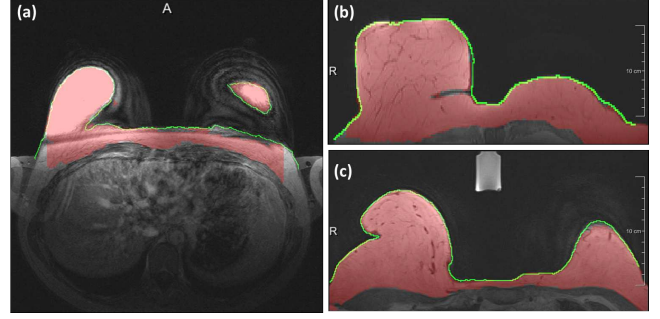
The artifacts and challenges presented in breast MRI, overlaid with the segmented breasts (red masks), and the reference breast-air boundaries annotated by a radiologist (green contours): (a) Presence of aliasing artifacts (ghost shadow). (b) Absence of the left breast. (c) Presence of fiducial markers
